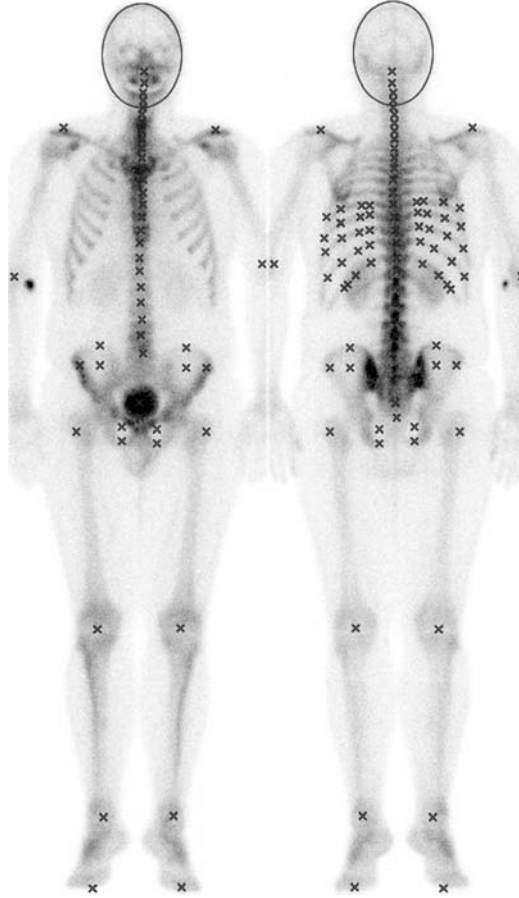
Defined characteristic reference points on anterior (left) and posterior (right) whole-body bone scintigrams.
